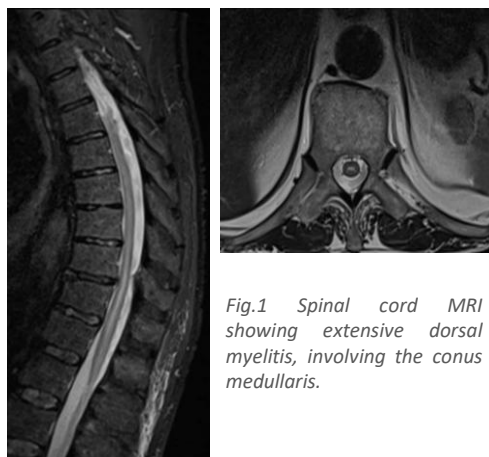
Spinal cord MRI showing extensive dorsal myelitis, involving the conus medullaris.
